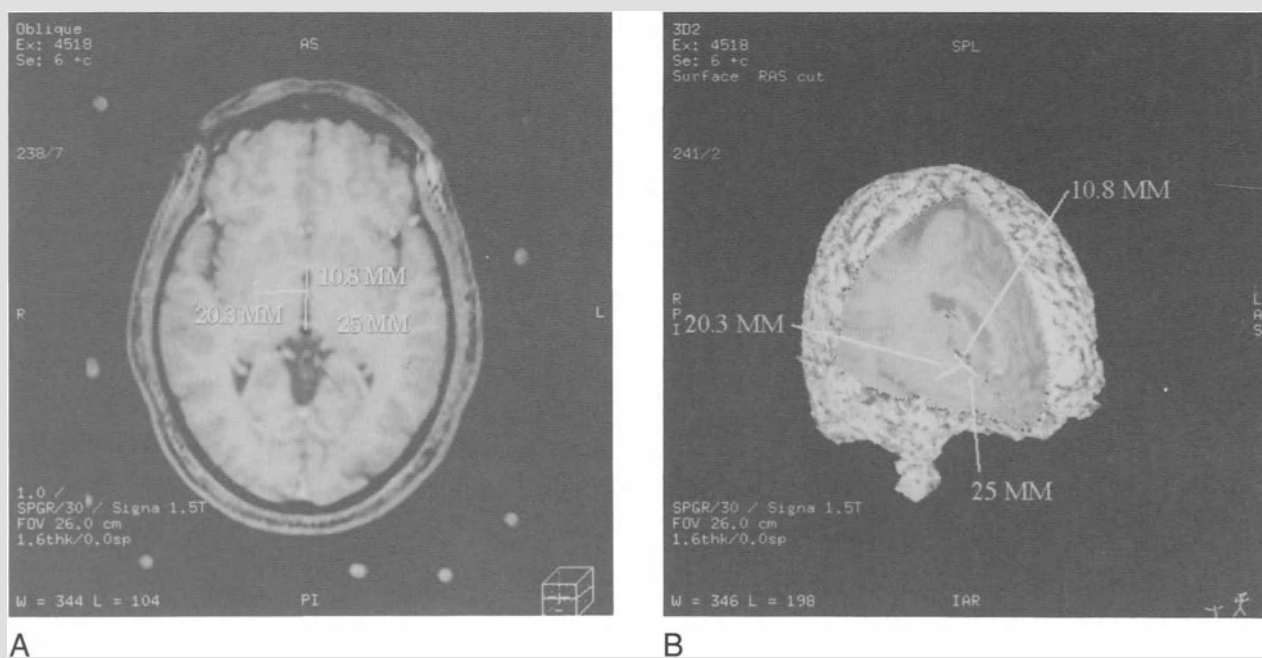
(A) Pre-operative volumetric MRI with single slice for localization at intercommissural plane. (B) Pre-operative 3D volume surface-rendered study with cut-out at intercommissural plane. (C) Post-operative 3D volume surface-rendered study with cut-out at same level (see p. 35) (Arrow: epicenter of superior portion of lesion)
